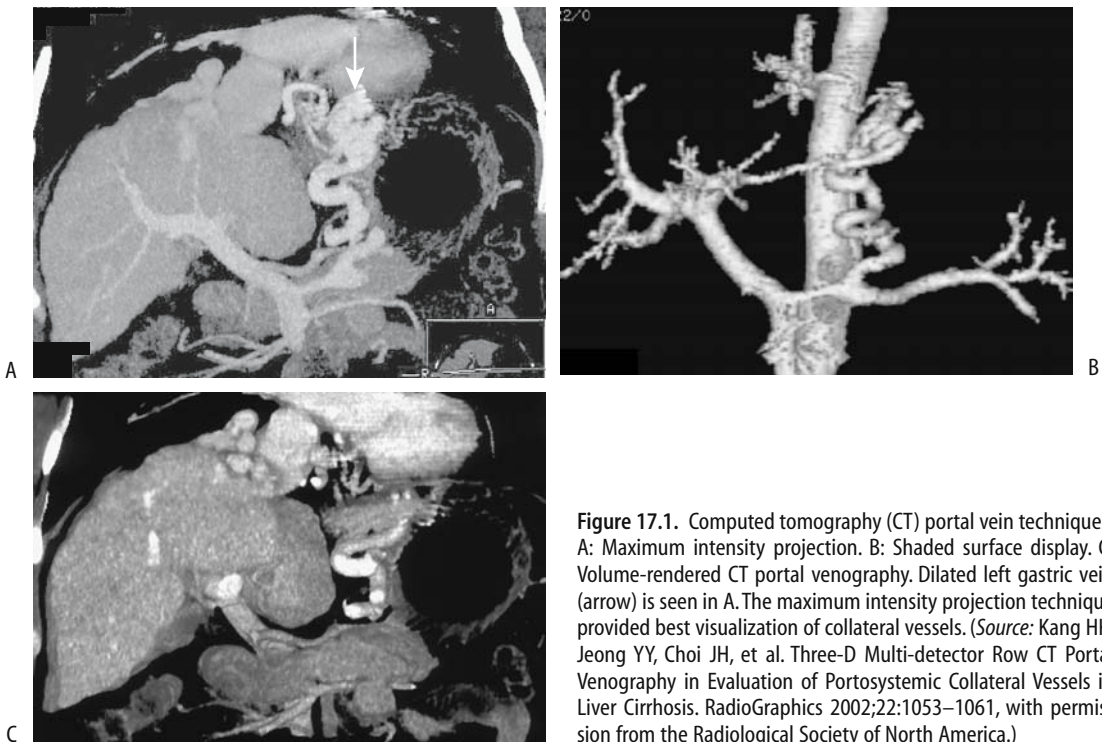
Computed tomography (CT) portal vein techniques. A: Maximum intensity projection. B: Shaded surface display. C: Volume-rendered CT portal venography. Dilated left gastric vein (arrow) is seen in A. The maximum intensity projection technique provided best visualization of collateral vessels. (Source: Kang HK, Jeong YY, Choi JH, et al. Three-D Multi-detector Row CT Portal Venography in Evaluation of Portosystemic Collateral Vessels in Liver Cirrhosis. *RadioGraphics* 2002;22:1053–1061, with permission from the Radiological Society of North America.)
